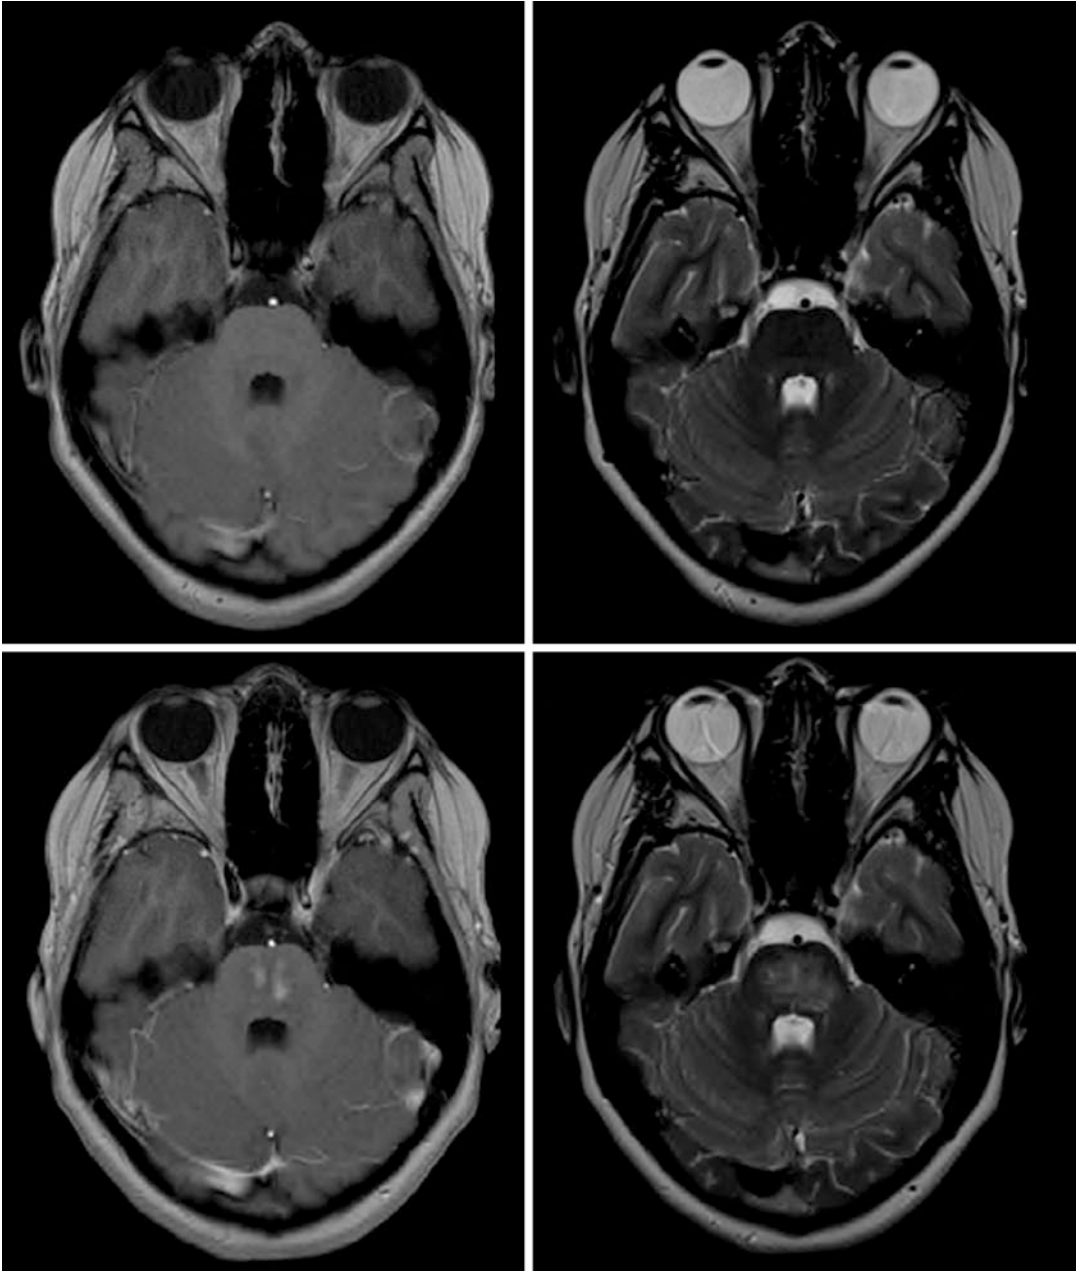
Example of brainstem necrosis and response to hyperbaric oxygen therapy. MRI 6 weeks after the completion of proton therapy (*first row*), MRI 12 weeks after
